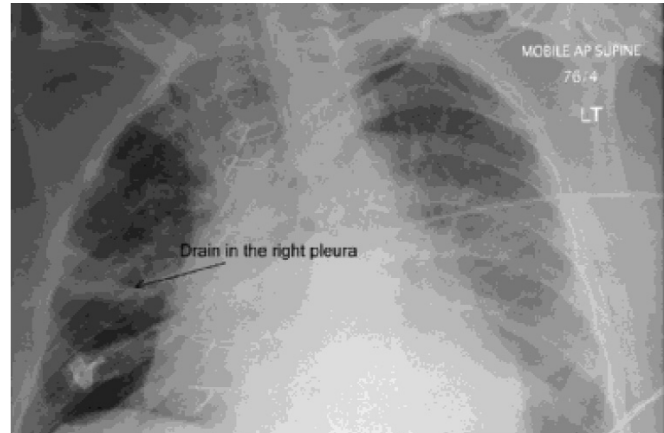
Chest radiograph showing the inserted Bonanno catheter at the base of the right-sided lung-to-drain pleural effusion.
